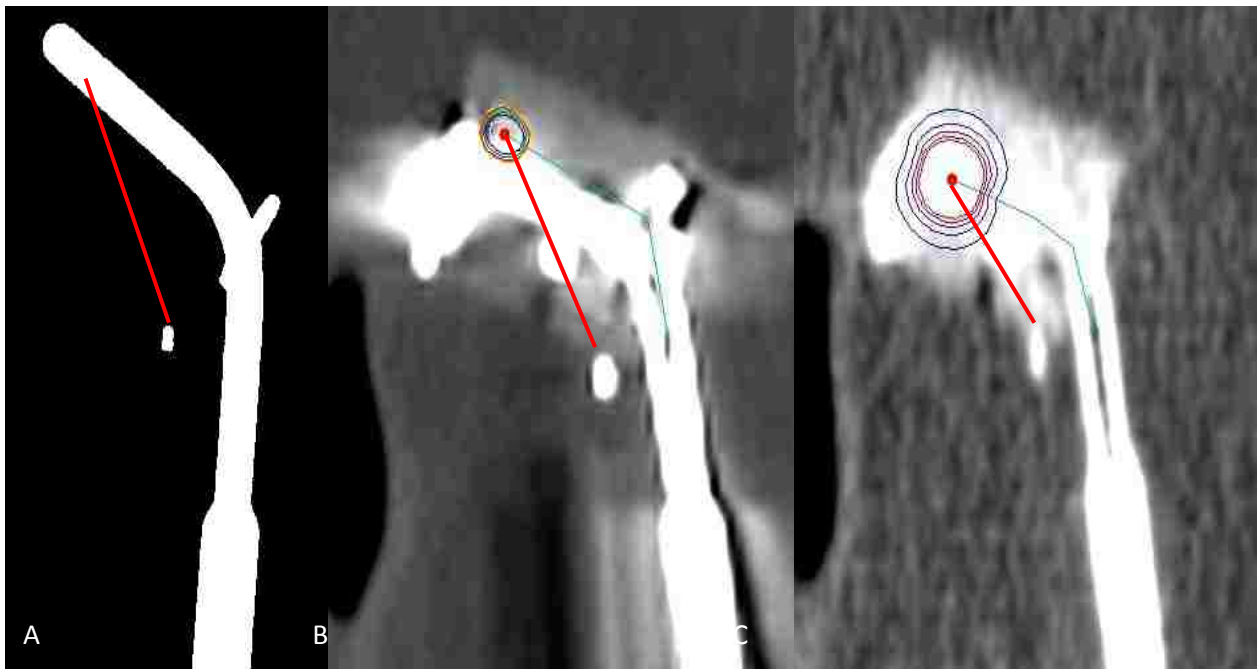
Method of determining the accuracy of the participant-defined source dwell position. (A) Scan of the radiograph from which control distances were measured. (B) kVCT and (C) MVCT of the left ovoid for the FSDs applicator.
